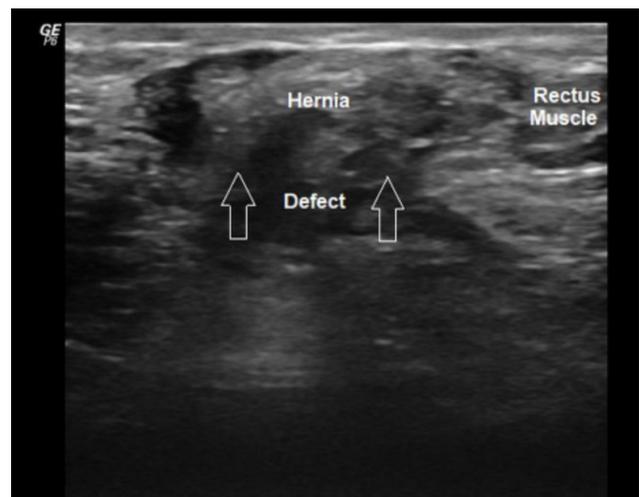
Superficial soft tissue ultrasonography showing bulging in Pfannenstiel incision site.
